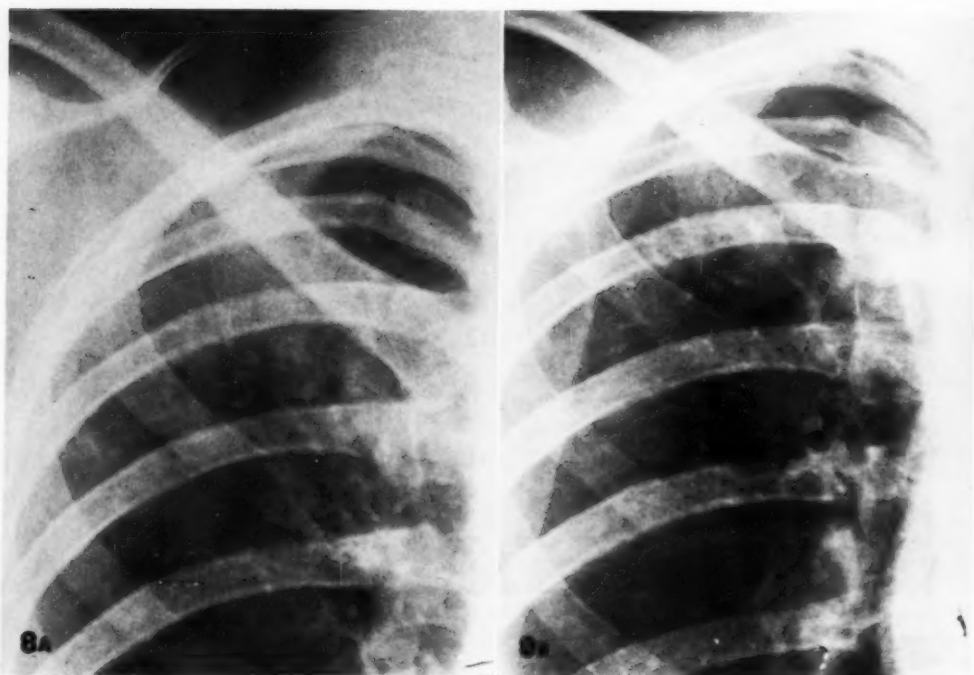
Case reported by Beeson (2). A. Detail of roentgenogram taken Feb. 9, 1943, showing small infiltrates in the right upper lobe. B. Same patient eight years later (Jan. 8, 1951), showing fibrosis and calcification of the infiltrates.
